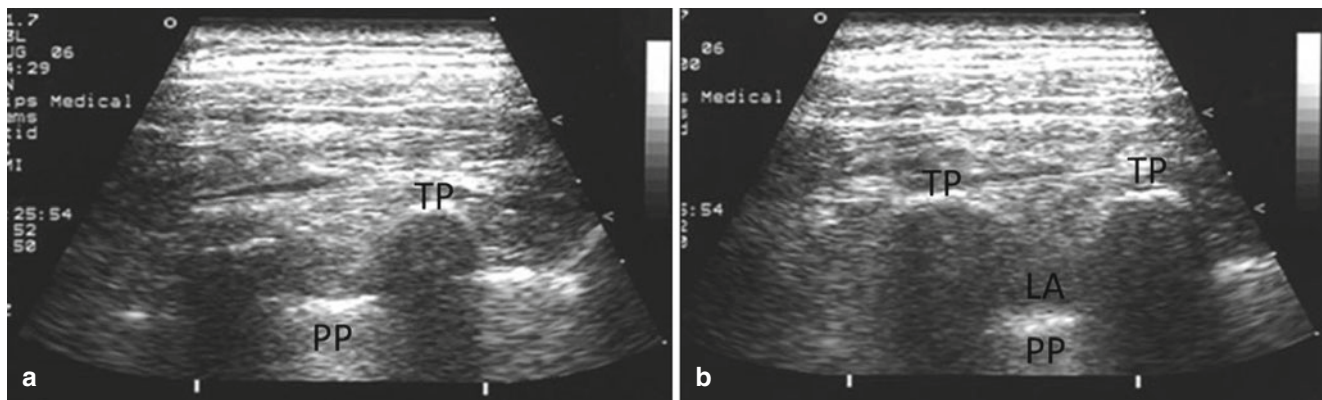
Paramedian sagittal thoracic paravertebral block. Visualization of local anesthetic and the downward shift of parietal pleura on ultrasound longitudinal image. (a) Before injection, (b) after
